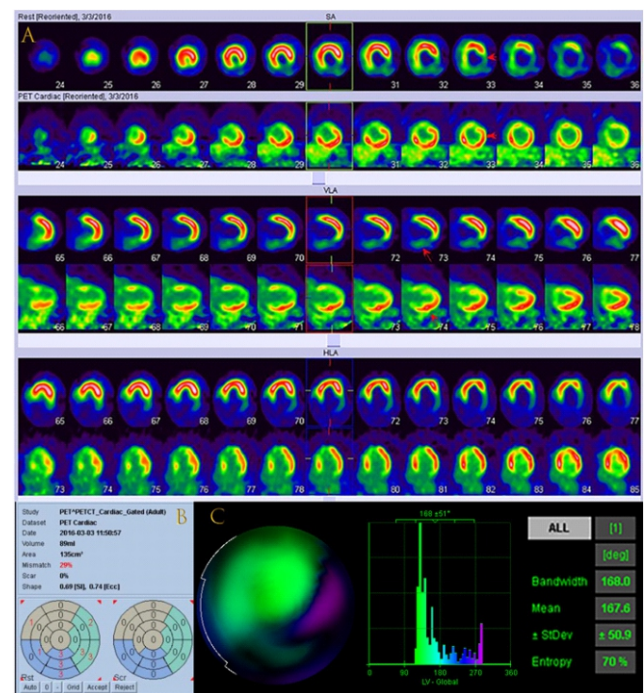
Images of a 70 years old male MI patient with tri-vessels disease (LVEF: 18%). A: Results of $^{99\text{m}}\text{Tc}$ -MIBI SPET/ ^{18}F -FDG PET. Rows 1, 3 and 5 are gSPET MPI images, and rows 2, 4 and 6 are ^{18}F -FDG PET myocardial metabolic images. Technitium-99m-MIBI SPET images show perfusion defects of the inferior wall, lateral wall and posteroseptal wall. All above segments have ^{18}F -FDG uptake, suggesting that they are hibernating myocardium. B: QPS shows mismatch of 29% and scar of 0%. C: Phase analysis shows non-uniform left ventricular phase polar map, asymmetric, multi-peak and wide phase histogram which has phase bandwidth of 168° and phase standard deviation of 50.9° , suggesting that LVMD is present.
